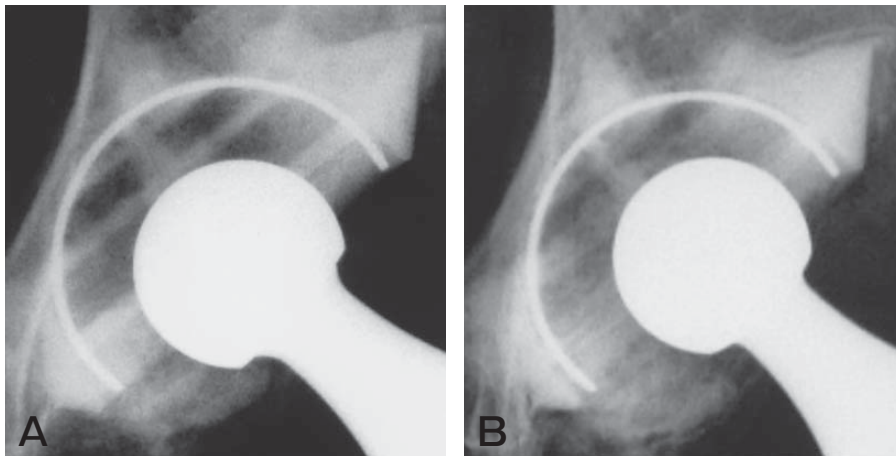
Radiograph of a 70 year-old female who underwent THA with a zirconia head for the right hip joint (OA) when she was 57 years old. No remarkable loosening was observed in the socket or the stem side at the final examination 13.2 years after operation. A, Radiographs of the socket after primary THA; these images were taken immediately after operation; B, At 13.2 years after primary THA, the head had moved remarkably to the upper side and the average annual linear wear was 0.139 mm/year.
